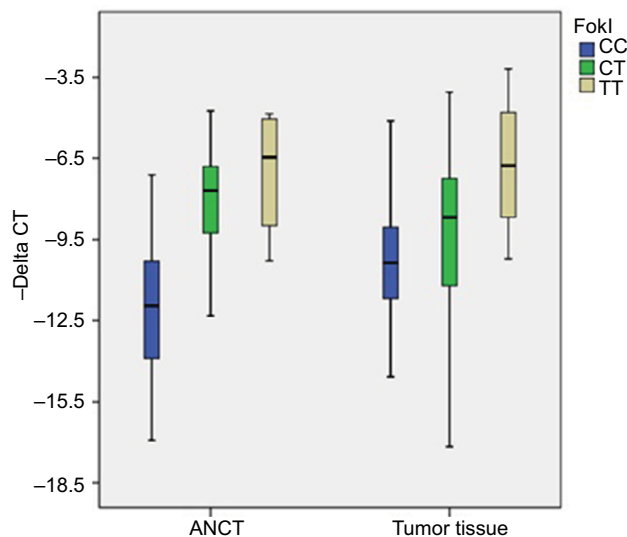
Relative expression of VDR ($-\Delta CT$ values = $CT_{B2M} - CT_{VDR}$) in association with different genotypes of FokI polymorphism.
